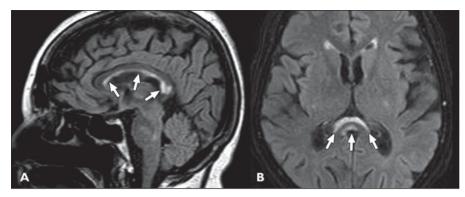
53-year-old alcoholic woman with Marchiafava-Bignami disease during subacute phase. A, Sagittal FLAIR image shows signal intensity alteration involving inferior aspect of corpus callosum (*arrows*). B, Axial FLAIR image depicts two curvilinear hyperintensities (*arrows*) in splenium of corpus callosum.
